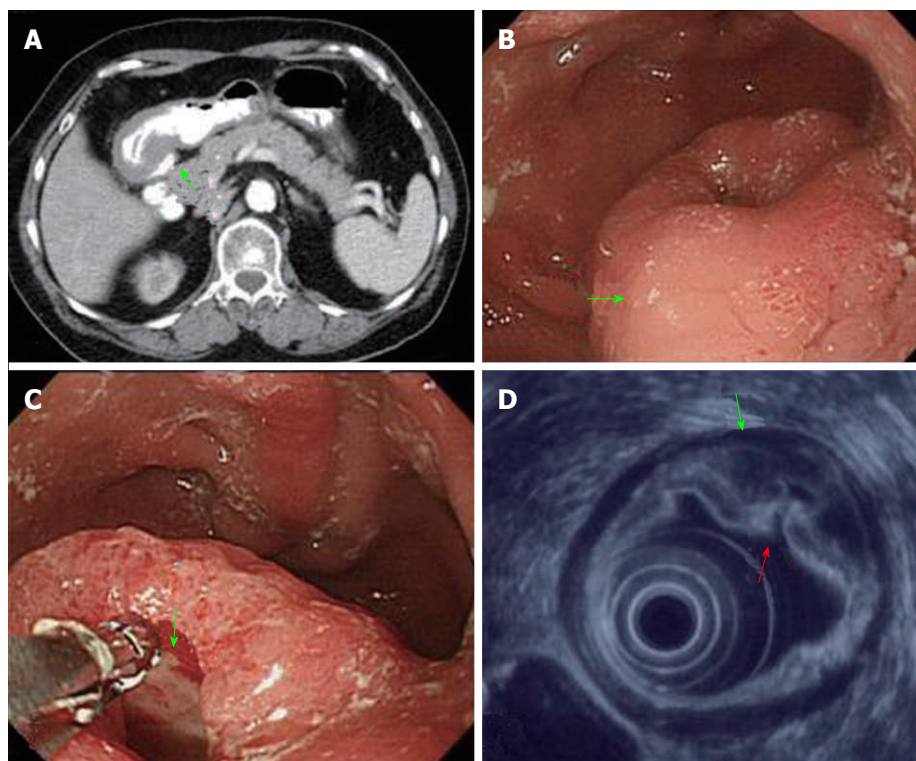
Image findings of gastric Peutz-Jeghers type stomach polyp. A: Abdominal computed tomography scans of the patient revealing a thickened gastric wall over the antrum of the stomach (arrow); B: Gastroendoscopy revealing a bulging lesion (4 cm × 3 cm) of the antrum (arrow); C: The bulging lesion displayed a central hole (arrow); D: Endoscopic ultrasonography demonstrating that the appearance of a lesion was due to a thickened subepithelial layer (second layer lesion), submucosal layer thickened (third layer, green arrow), and corresponding hole (red arrow) over the antrum of the stomach.
